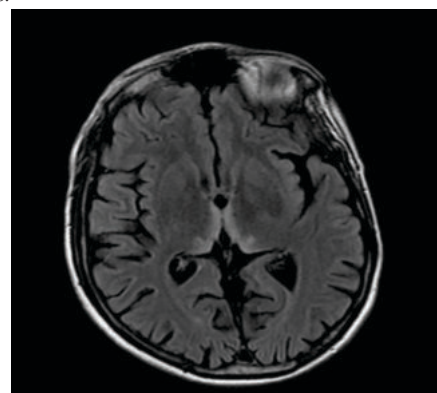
T2 FLAIR MRI of the brain demonstrates hyperintensities in the periaqueductal region and the medial thalami. Cerebral atrophy is also seen in this case.
